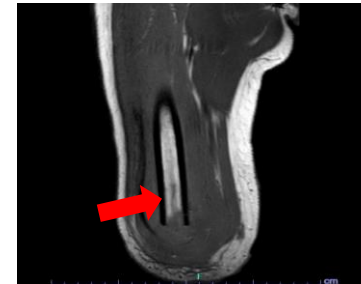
MRI of RLE amputation site, denoting area of concern for infection
